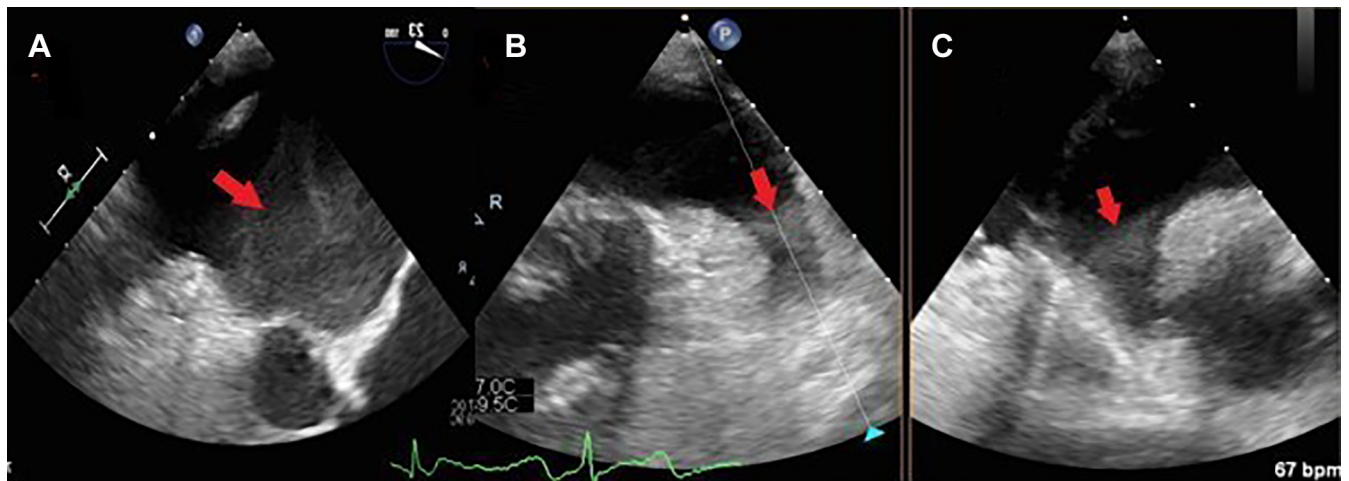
Transesophageal echocardiogram (TEE) images. A: TEE of the left atrium showing marked echo contrast (arrow). B,C: TEE of the left atrial appendage in orthogonal planes showing “sludge” (arrow).
